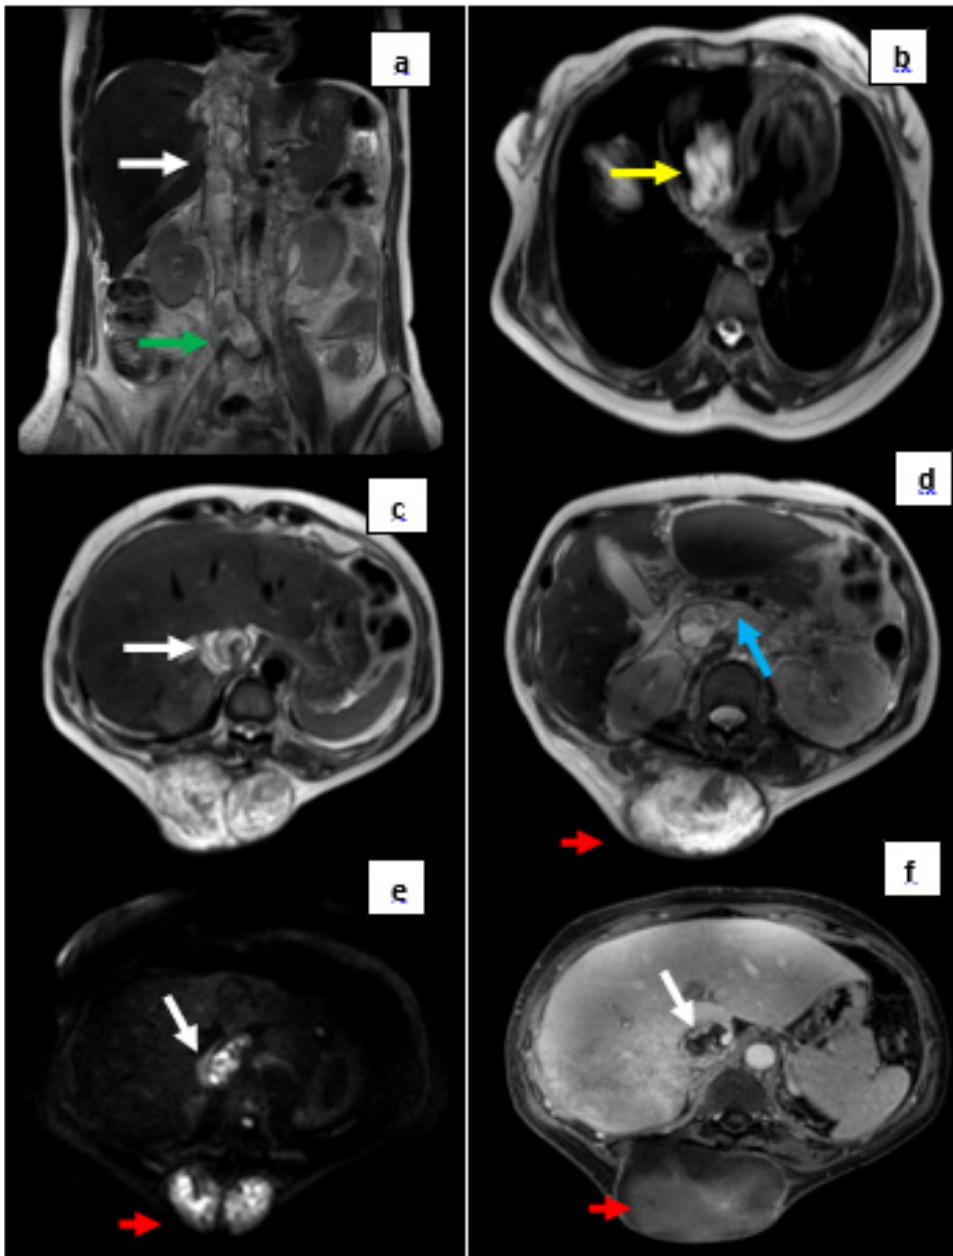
Abdominal MRI revealed tumoral venous invasion of the Inferior Vena Cava (IVC) (white arrows) (a) extending to the right atrium (Yellow arrow) (b), renal veins (Blue arrow) (d), and common iliac veins (Green arrow) (a), with hypersignal on T2-weighted imaging (a,b,c,d), restricted diffusion (e), and moderate enhancement after Gadolinium injection (f). The dorsal myxofibrosarcoma appeared as hypersignal on T2-weighted imaging, restricted diffusion, and showed moderate enhancement after Gadolinium injection (Red arrow).
